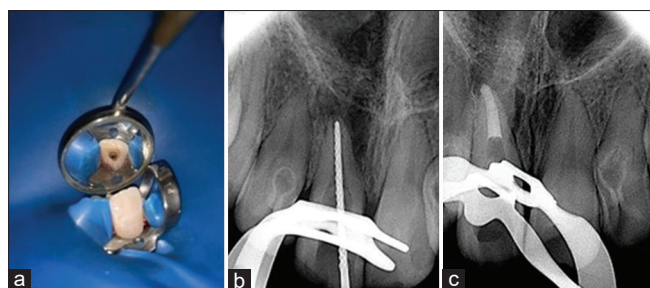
(a) Access cavity; (b) working length determination radiograph; (c) Apical mineral trioxide aggregate plug placement
